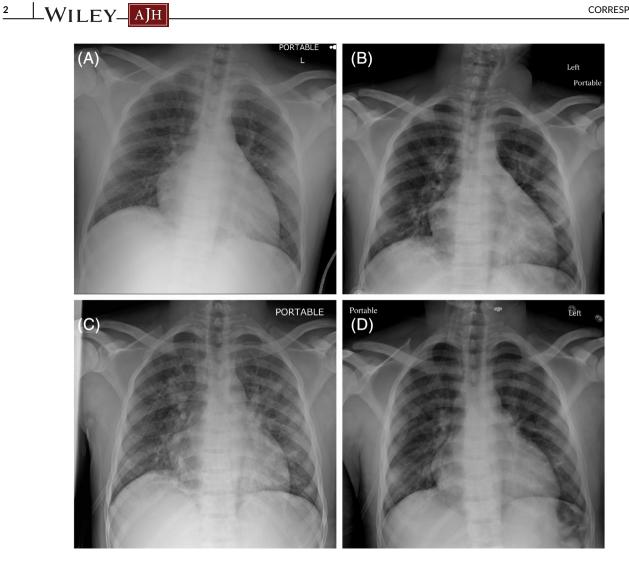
Progression of COVID-19 pneumonia to acute chest syndrome and response to exchange transfusion. A. Chest X-ray on hospital day 5 without evidence of pneumonia. B, Chest X-ray on hospital day 10 with multifocal ill-defined opacities in the left mid-lung, retro-cardiac portion of the left lower lobe and right lung base. C, Chest X-ray on hospital day 11 with worsening diffuse ground-glass- and reticular opacities. D, Chest X-ray on hospital day 13 status post exchange transfusion with improvement in diffuse ground glass opacities
